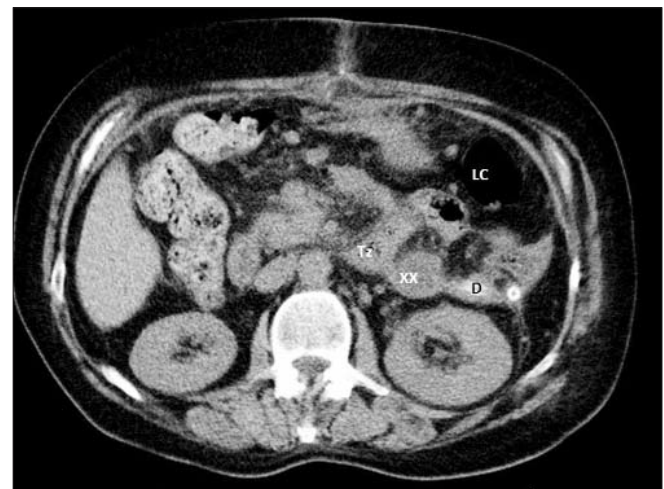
CT scan (native) - Placement of the drain using the submesocolic approach - Treit's angle access. Tz - Treitz angle; XX - remnant collection; D - drain; LC - left colic angle
